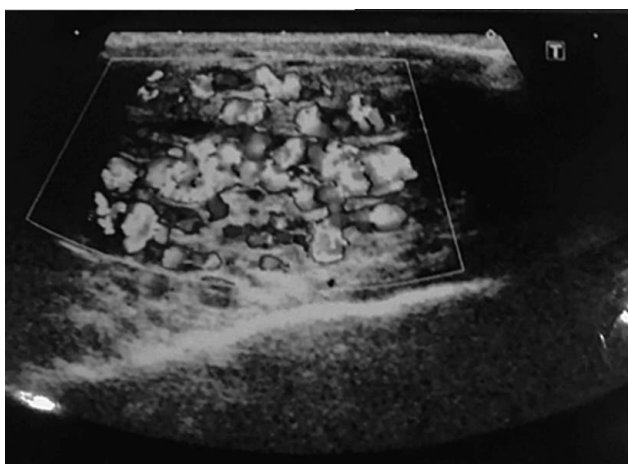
Ultrasonography of the left temporo-parietal scalp showing multiple tortuous serpentine vascular channels, indicative of a scalp arteriovenous malformation.
